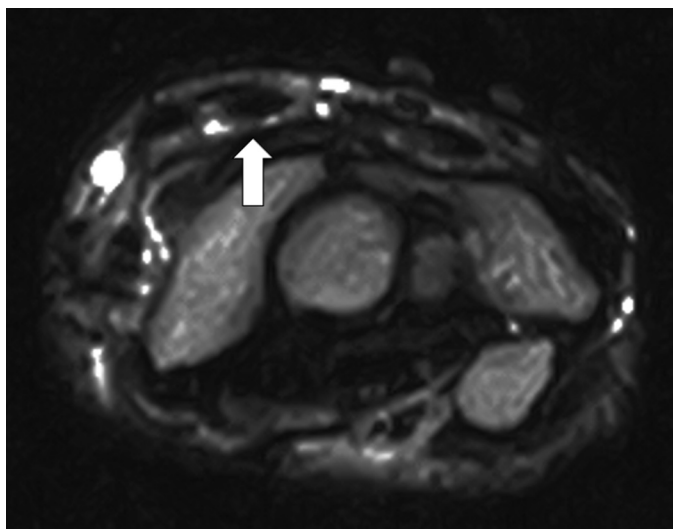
Magnetic resonance image (T2-weighted image) taken at the patient's initial visit. The high signal area around the ECRB tendon (white arrow) is shown.
